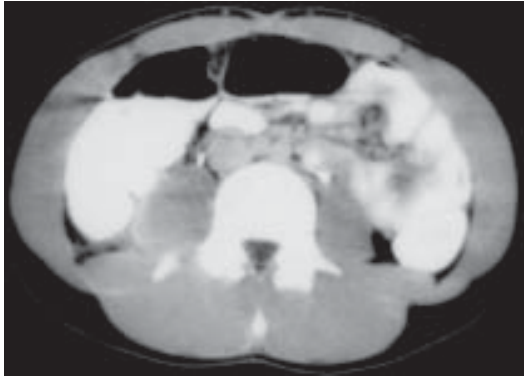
Computed tomography of the pelvis revealing prominent asymmetry of the right psoas vs the left, consistent with psoas hemorrhage. Soft tissue density extending along the right ileum is the residua of retroperitoneal hemorrhage. Femoral nerve entrapment was associated with this traumatic injury.
